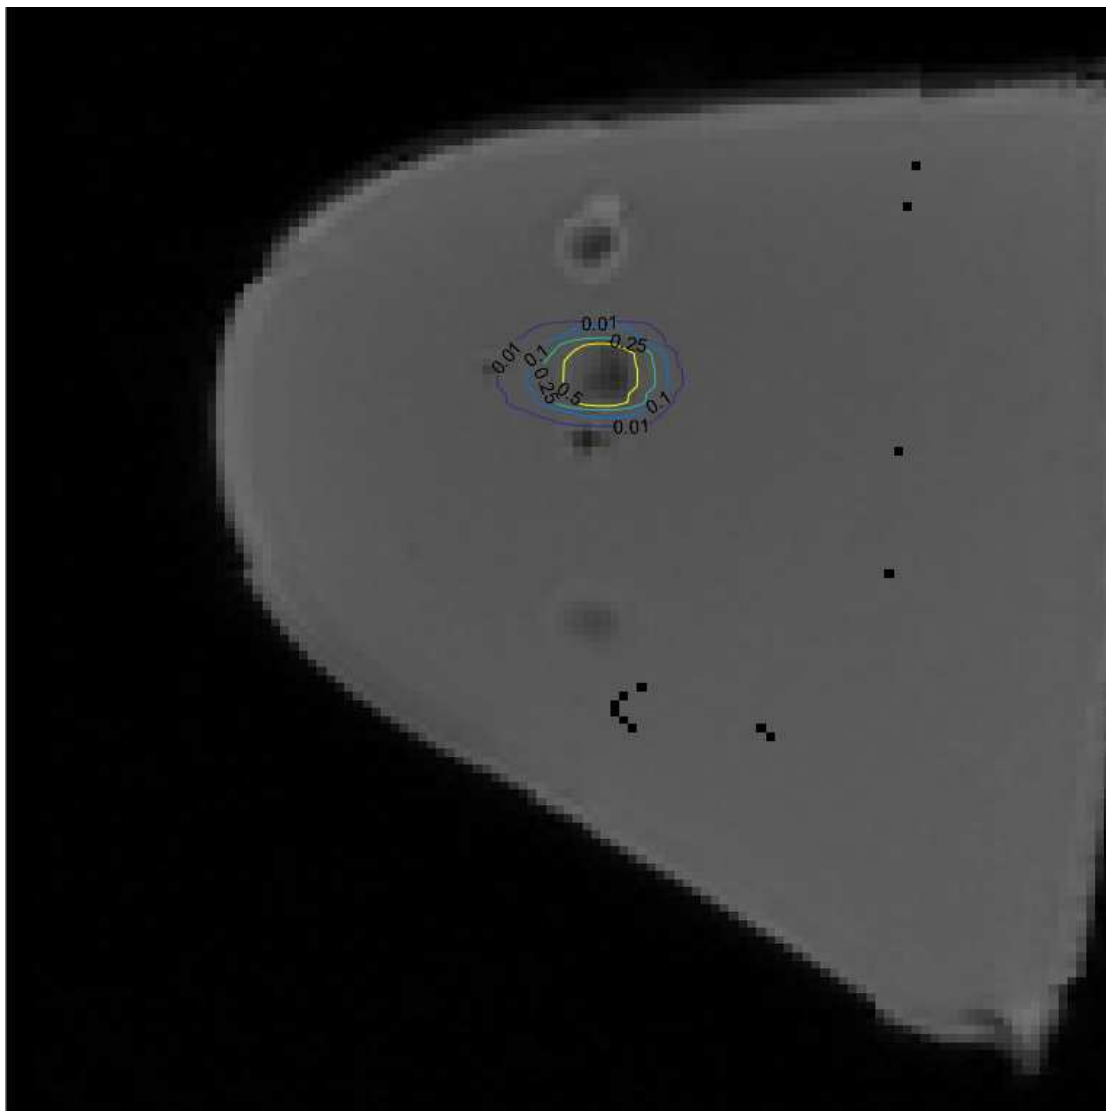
Isocontours at levels/heights 0.01, 0.1, 0.25, and 0.5 extracted from the approximate expected deformed example ROI MLPs 2D cross section that is visualized in Figure 3.15 overlaid over the MAP deformed MRI cross section estimate from Figure 3.4.
